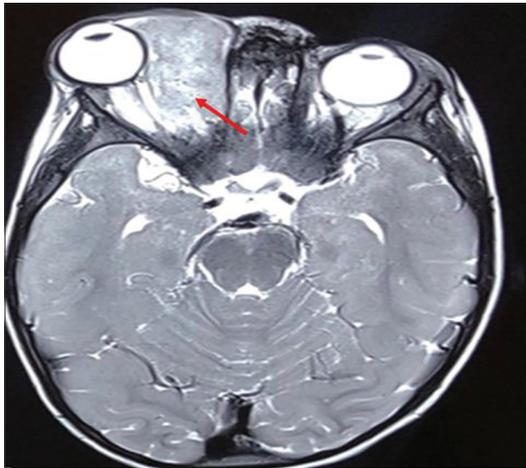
Magnetic resonance imaging showing T2 hyperintense mass lesion in the medial aspect of orbit.
